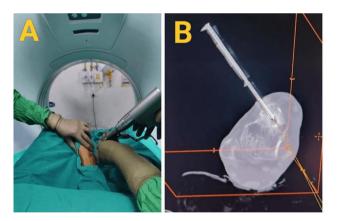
(A) Clinical photograph in the computed tomography scan console room and (B) axial CT cuts confirming the position of the 6.5 mm cannulated drill bit over guide-wire passed to the level of the nidus.
